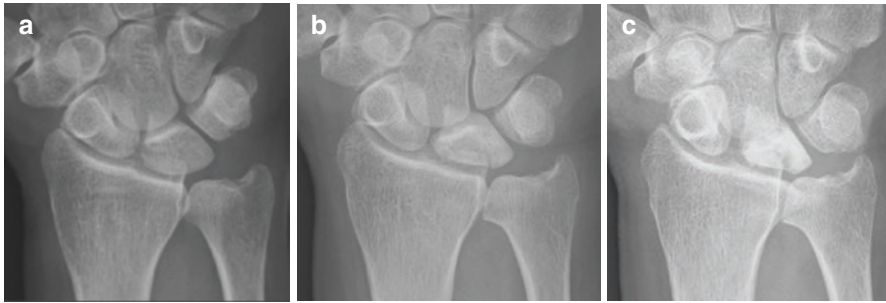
Progression of Kienböck's disease. (a) A 32-year-old woman. A radiograph was taken by chance 4 years before onset. (b) The patient complained of mild wrist pain without acute trauma. Plain radiograph represents lunate collapse without carpal collapse. (c) Eight months later, the lunate further collapsed, and the capitate migrated proximally
